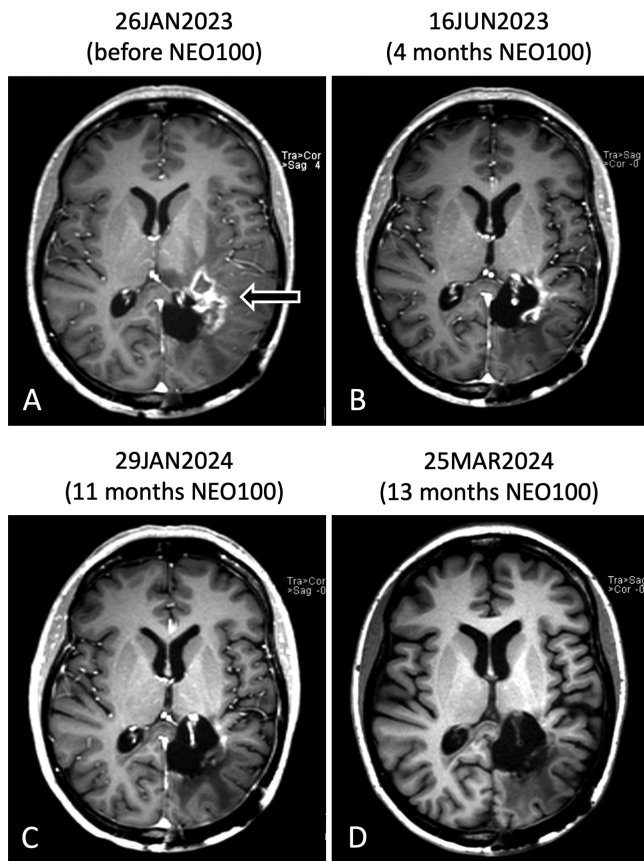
Postcontrast T1-weighted 3D spoiled gradient recalled echo (SPGR) images were obtained. A: After recurrence, a baseline study before the onset of treatment with NEO100 (January 2023). The tumor burden appears adjacent to the resection cavity (arrow) and was $3.7 \times 2.8 \times 4.6$ cm in size. B: At 4 months after the initiation of treatment (June 2023), there appears to be less size at the location of tumor recurrence. C: At 11 months (January 2024), tumor tissue size is further reduced. D: At 13 months (March 2024), there is no apparent nodular enhancement at the location of tumor recurrence. These findings are consistent with disease remission, by both the MacDonald and RANO (Response Assessment in Neuro-Oncology) criteria.
